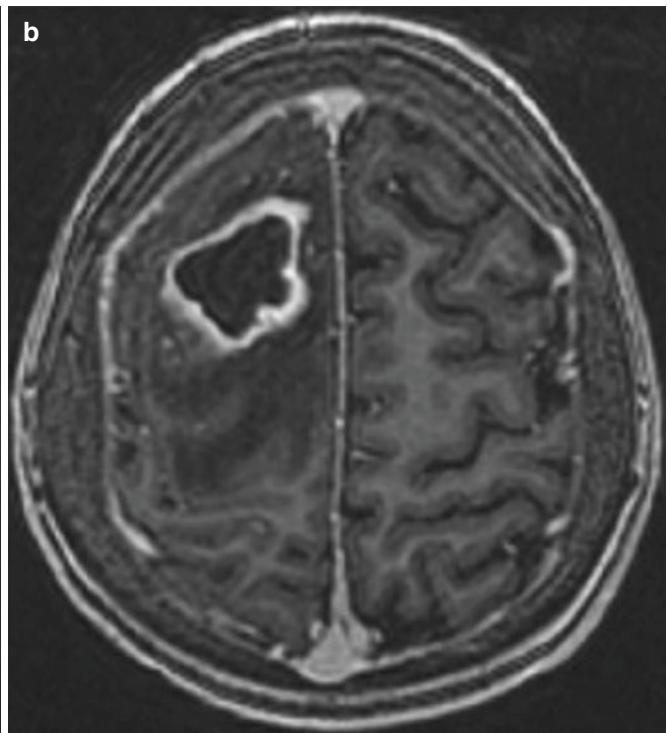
Right frontal cerebral abscess. (a) Axial T2-weighted MR image shows a high-signal abscess with a low-signal wall in the superior right frontal lobe. There is marked surrounding brain oedema. (b)
